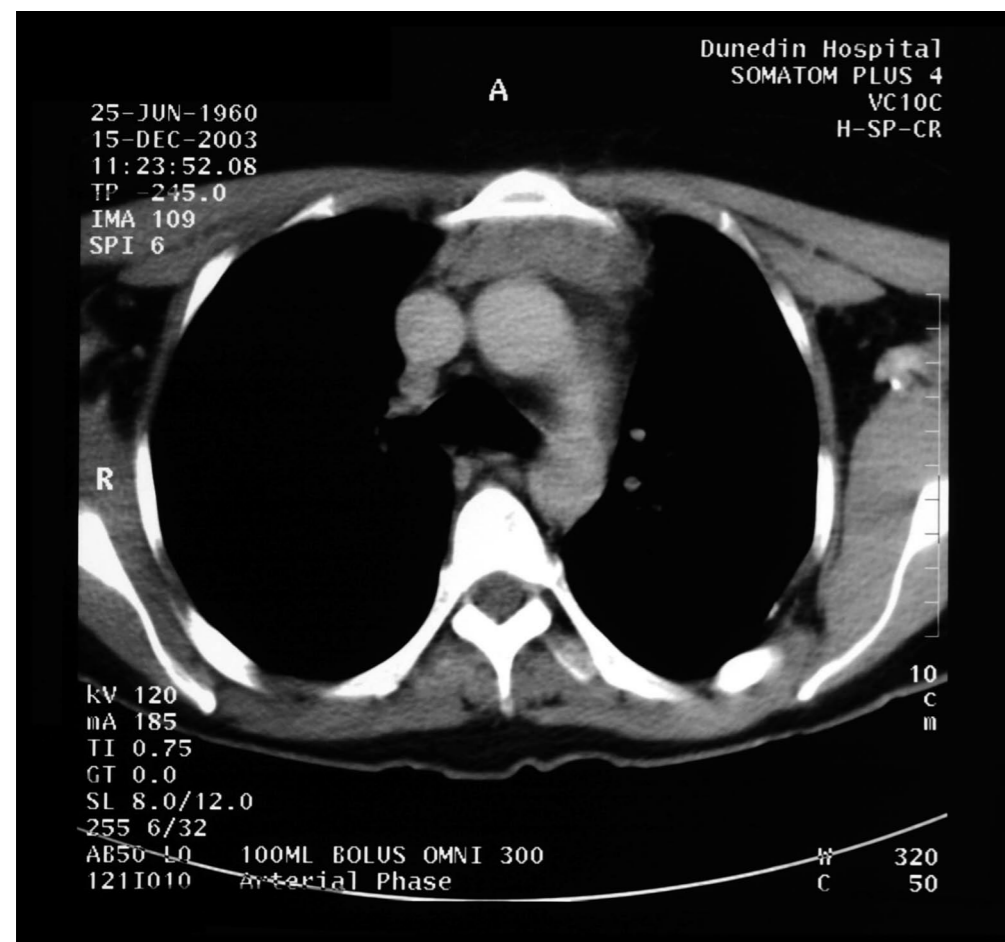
Contrast-enhanced CT scan of neck and mediastinum indicating hyperthyroidism.
